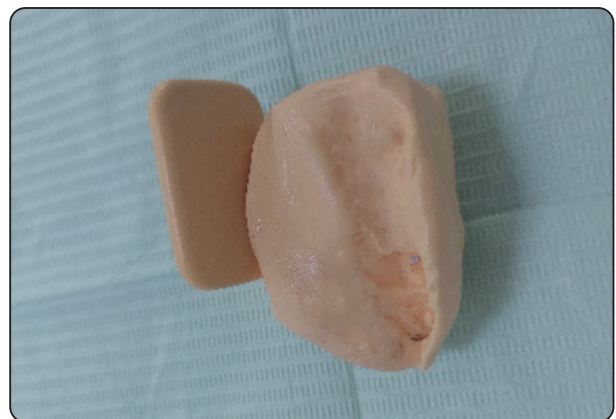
Customized bite block for standardization of x-rays
